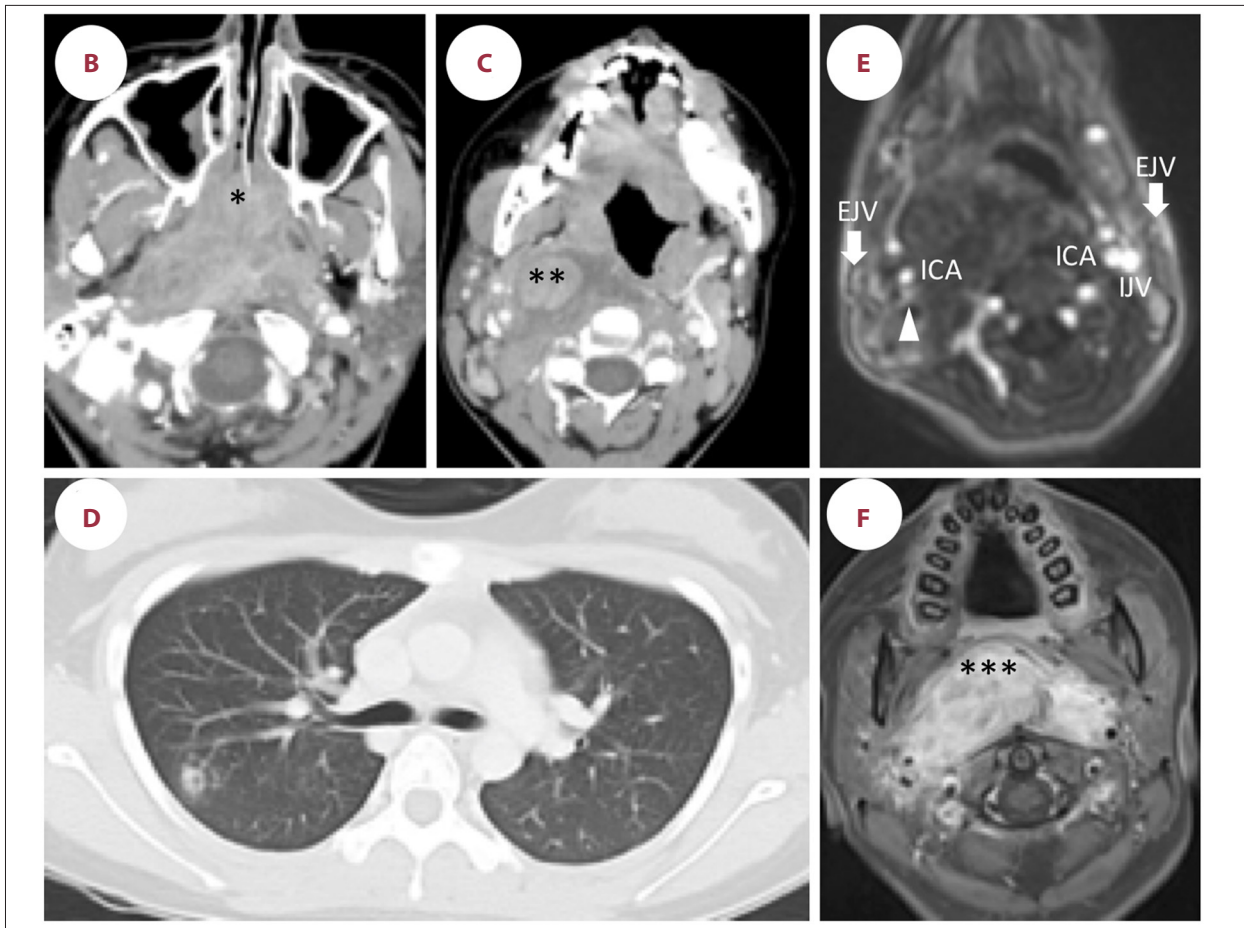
Clinical course and imaging studies. (A) Clinical course. (B, C) Contrast-enhanced axial computed tomography (CT) scan on admission demonstrated a large mass lesion filling the nasopharynx with extension into the right parapharyngeal space and marked swelling of the right deep cervical lymph nodes. (D) CT scan obtained on day 5 after first admission shows a nodule with central cavitation in the right lung. Other nodules are not shown in this slice. (E) Magnetic resonance angiography on hospital day 12 after second admission demonstrated the stenotic right internal jugular vein (arrowhead) and internal carotid artery. (F) Axial T1-weighted contrast material-enhanced magnetic resonance imaging (MRI) at the level of the nasopharynx on hospital day 34 after second admission demonstrated a well-enhanced massive tumor infiltrating into the right and left parapharyngeal space. An asterisk, double asterisks, and triple asterisks indicate the site of first biopsy, second biopsy, and third biopsy, respectively. ICA – internal carotid artery; IJV – internal jugular vein; EJV – external jugular vein; CRP – C-reactive protein; PSL – prednisolone; DEX – dexamethasone; CLDM – clindamycin; PIPC – piperacillin; MINO – minocycline; MNZ – metronidazole; ABPC/SBT – ampicillin/sulbactam; MEPM – meropenem; PCG – benzylpenicillin.
